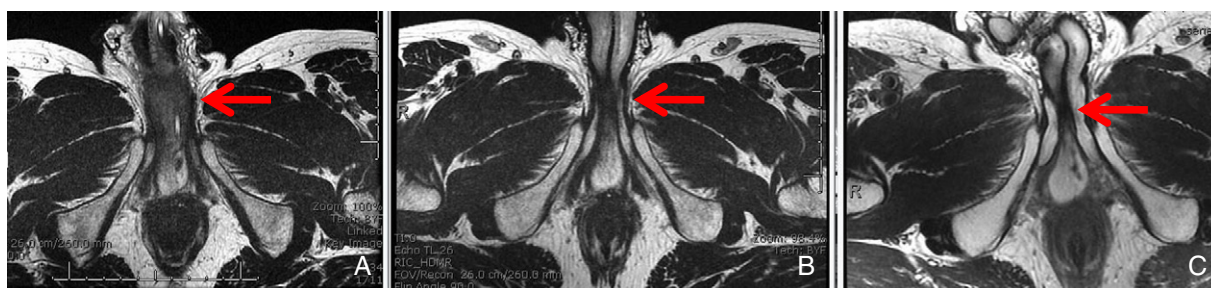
Axial T2 magnetic resonance imaging panel comparing tumor size (A) before treatment, (B) after induction chemotherapy, and (C) after concurrent chemoradiation therapy. The red arrow identifies the malignant lesion. Note the displacement of the Foley catheter in (A).
